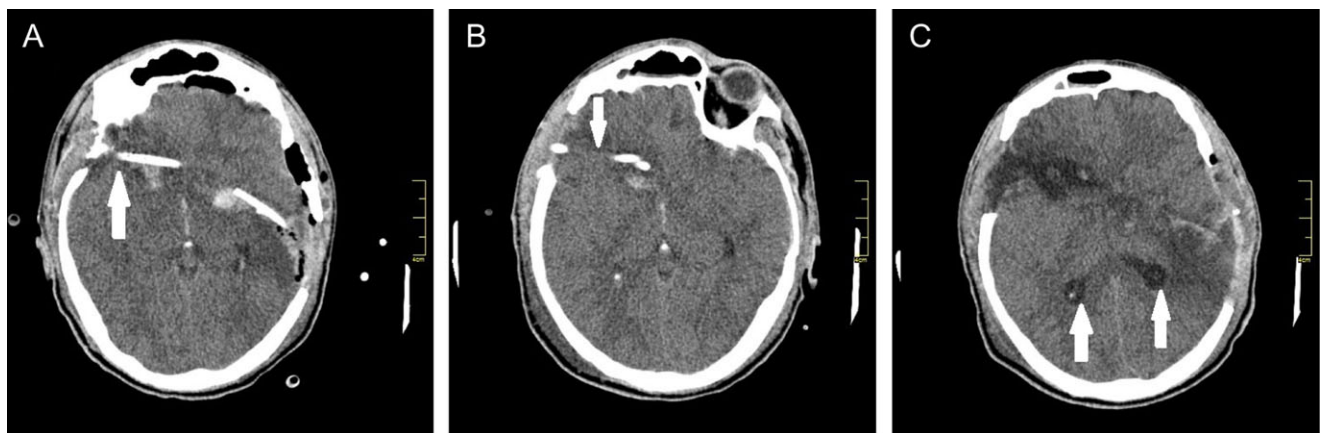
Brain computed tomography (CT) images showing (A) follow-up CT on day 1 following surgery and drainage, the absence of bone fragments in the wound channel (white arrow), (B) follow-up CT on day 2 after removal of drains, reduction of blood accumulation along the wound channel (white arrow) and (C) follow-up CT on day 5, lack of blood in the posterior horns of the lateral ventricles (white arrows).
